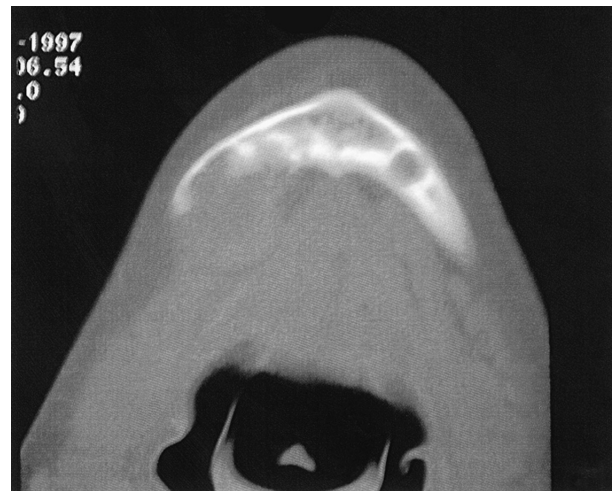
Axial CT image of a mandibular desmoplastic fibroma demonstrating extensive bony destruction and expansion into soft tissue (from Kaban, Troulis, eds. *Pediatric Oral and Maxillofacial Surgery*, Saunders, Philadelphia, 2004, with permission).
